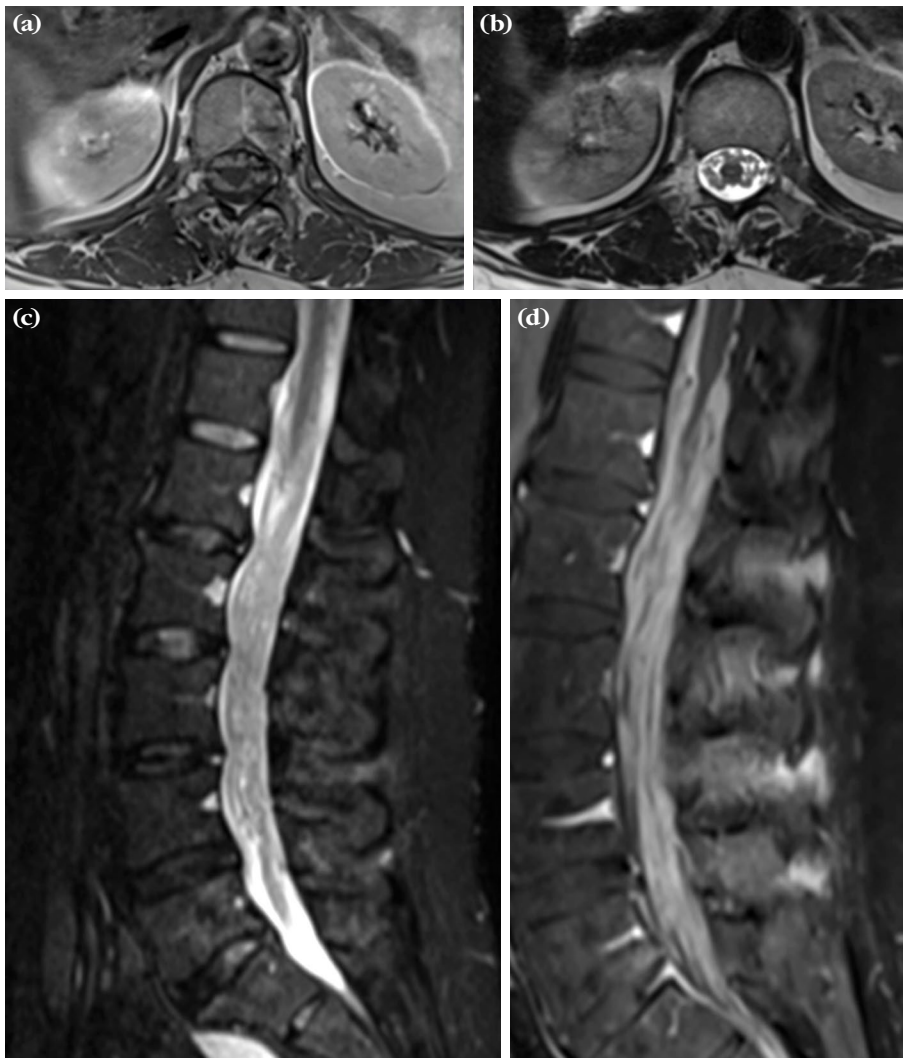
T1- and T2-weighted images of (a, b) axial and (c, d) sagittal magnetic resonance imaging showing thickening of the lumbosacral roots without contrast enhancement.
